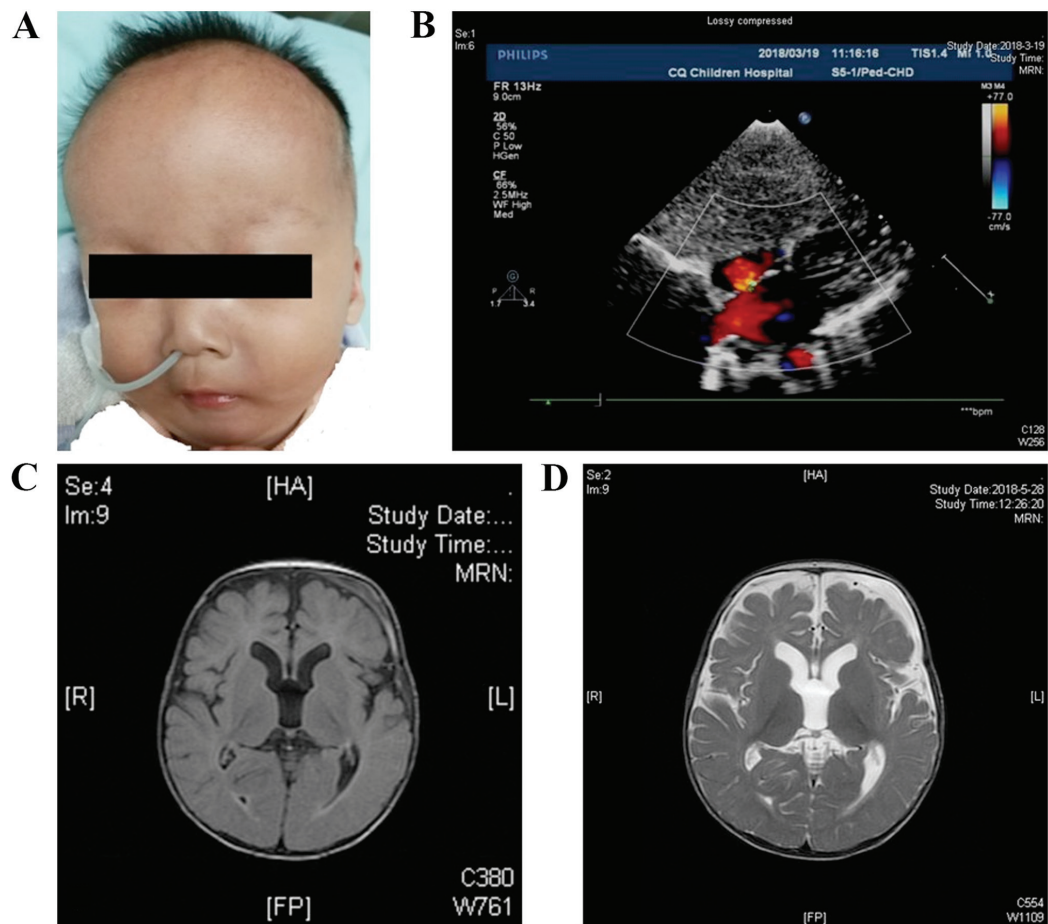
(A) Photograph of the patient (9 months), facial dysmorphism including frontal bossing, low set ears, depressed nasal bridge, ocular hypertelorism, and micrognathia. (B) The atrial septum defect (red arrow, 4.5 mm) was detected through color Doppler ultrasonography. Magnetic resonance imaging (C) T1 and (D) T2 axial slices showed widened bilateral lateral ventricles and increased extracellular spaces.
